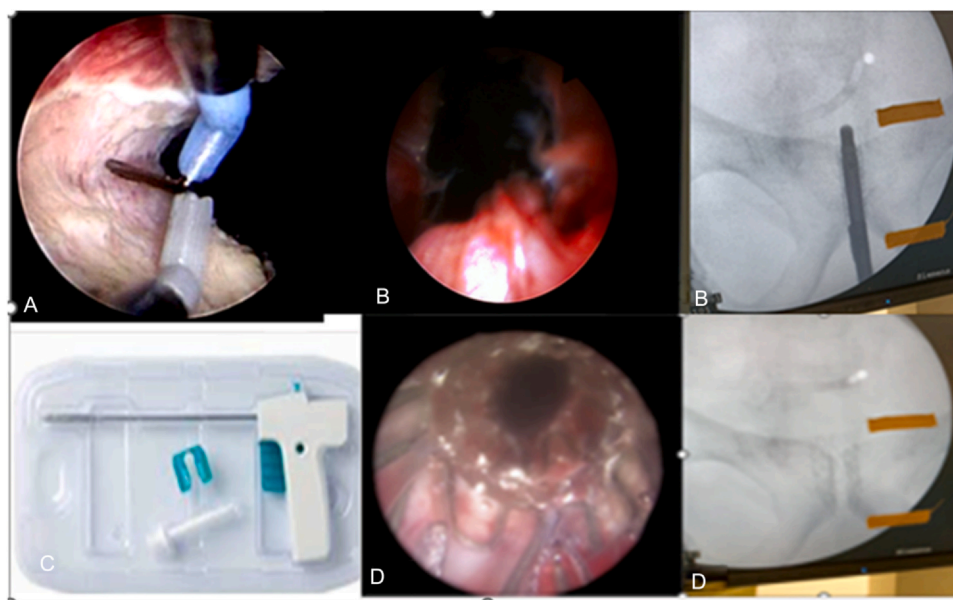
(A) Incision of fibrotic vesicourethral anastomosis till the fatty tissue. (B) Marking the level of vesicourethral anastomosis and urinary sphincter under x-ray. (C) The ready-to-use package of Allium Round Posterior Stent. (D) Endoscopic and fluoroscopic view of Allium Round Posterior Stent after insertion. (Color version available online.)
